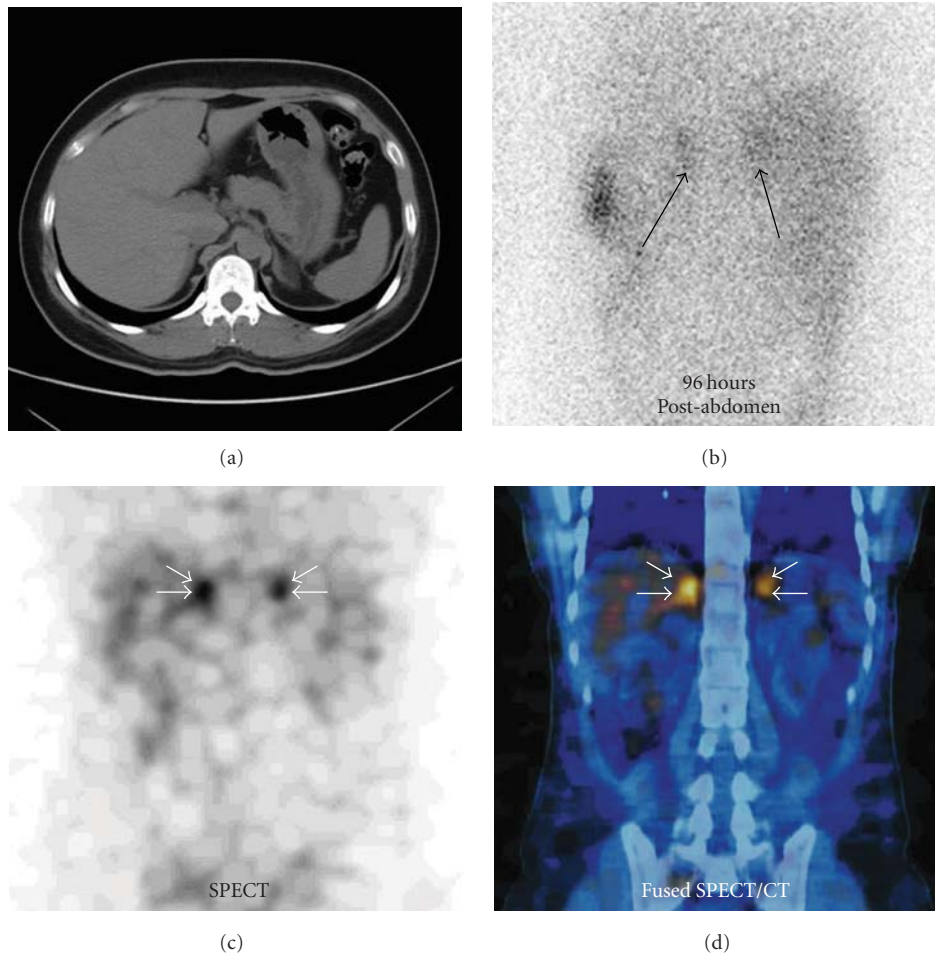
A 27-year-old woman (patient 15) who had stage 4 CKD presented with stage 1 hypertension alone due to bilateral adrenal hyperplasia, whose PAC was elevated, but whose serum potassium level was normal, whose PRA was nonsuppressive, whose ARR was negative, whose confirmatory testing was negative, whose bilateral adrenal lesions had normal appearing on CT (a) and faint uptakes on planar imaging (b) but true positive on SPECT (c) and coronal SPECT/CT (d) imaging. After treatment with 25 mg of spironolactone, her BP and PAC were normalized.
